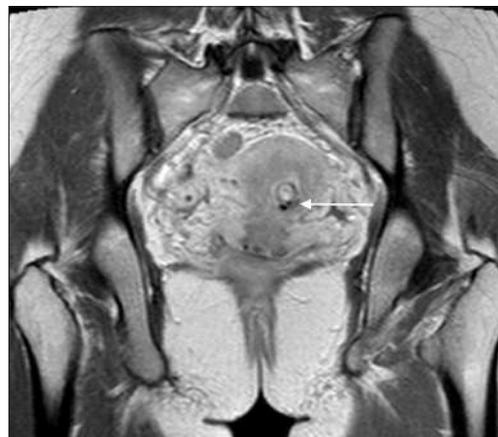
Coronal magnetic resonance imaging pelvis T1W post-intravenous gadolinium administration showing serpiginous low signal flow voids in the myometrium and endometrial cavity, consistent with a uterine arteriovenous malformation
